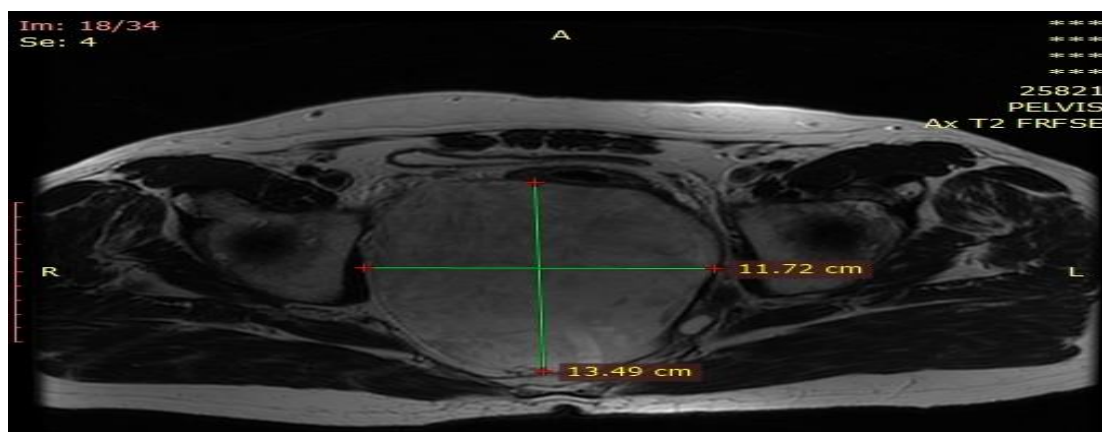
T2 weighted axial image of the tumor on MRI
